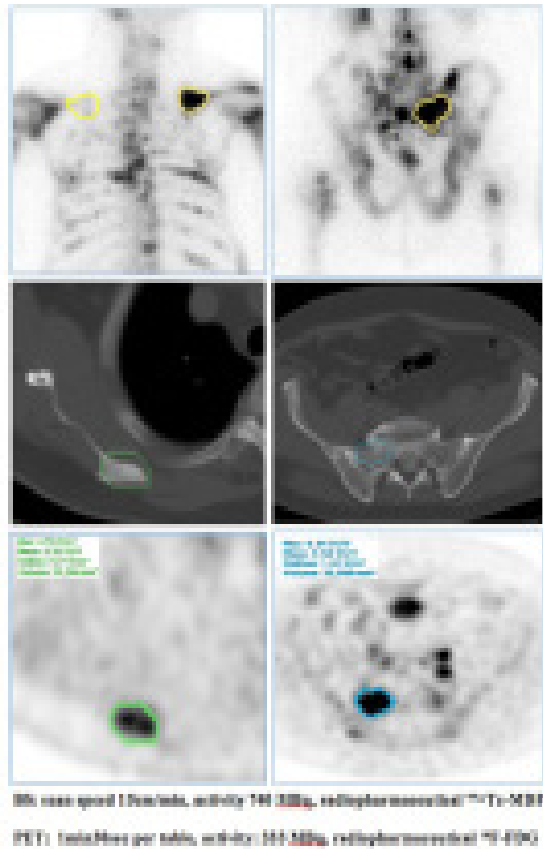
99mTc-MDP BS and 18F-FDG PET/CT scans in prostate cancer patient.
